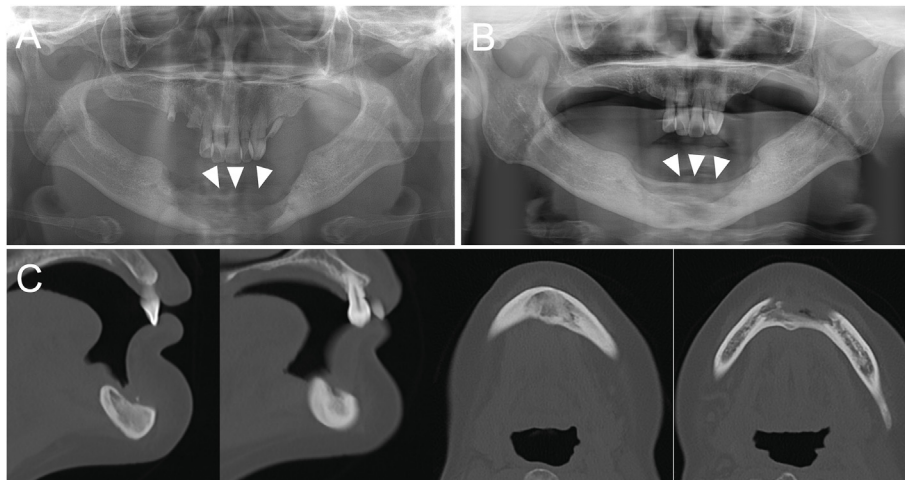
Postoperative radiographs of Case 4. (A) Panoramic view immediately after surgery showing postoperative bone defect (arrowhead). (B) Panoramic view at 32 months postoperatively, showing favorable bone healing with increased density and volume at the defect site (arrowhead). (C) Computed tomography images at 14 months postoperatively.
